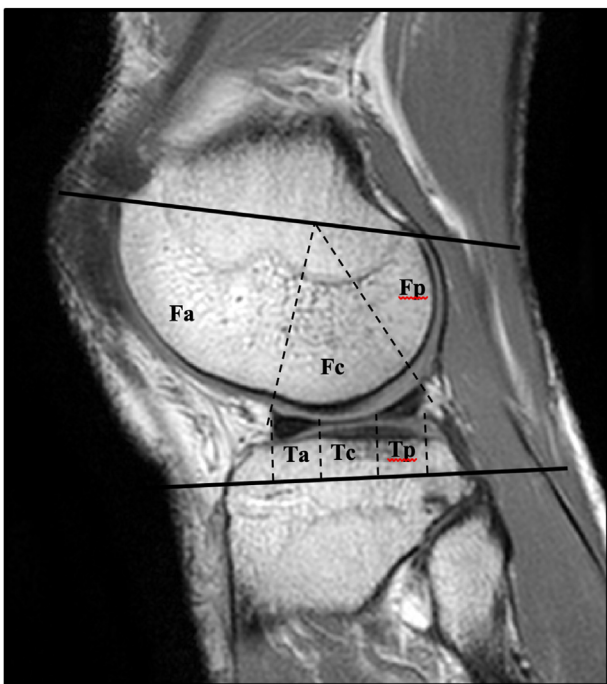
Whole-Organ Magnetic Resonance Imaging Score. The WOMBS classification assesses 15 distinct regions, subdivided by anatomical landmarks, in the fully extended knee. The patella is divided into lateral facet (LP) and medial facet (MP), including the patellar ridge within MP. The femoral articular surface is divided into medial condyle (MF) and lateral condyle (LF), with the trochlear groove considered part of MF. Each condyle is further subdivided into three regions: anterior (a), central (c), and posterior (p). The medial tibial plateau (MT) and lateral tibial plateau (LT) are also divided into three regions: anterior (a), central (c), and posterior (p). Using the WOMBS classification as a reference, the cartilage was divided in each sagittal image. Fa – femoral anterior; Fc – femoral central; Fp – femoral posterior; Ta – tibial anterior; Tc – tibial central; Tp – tibial posterior.
